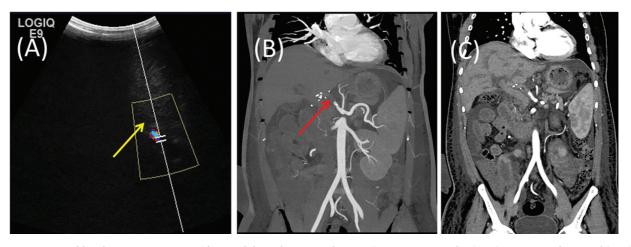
A 37-year-old male patient post DDLT (deceased donor liver transplantation) - postoperative day (POD) 4. Routine ultrasound (USG) Doppler surveillance (A) showed absent color flow (yellow arrow) in the intrahepatic portions of hepatic artery, raising the possibility of thrombosis. Contrast-enhanced computed tomography (CECT) abdomen coronal maximum intensity projection image (B) shows non-opacification of hepatic artery (red arrow) consistent with vascular thrombosis. CECT coronal multiplanar reconstruction images (C) show diffuse body wall edema with mild ascites.
